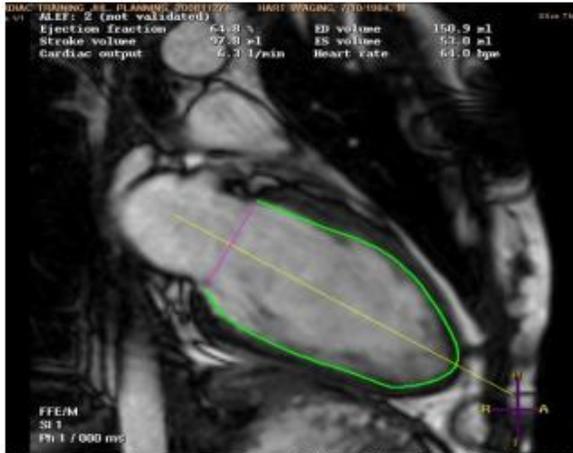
Measurement of the Ejection fraction in MRI. (Long axis sequences)
